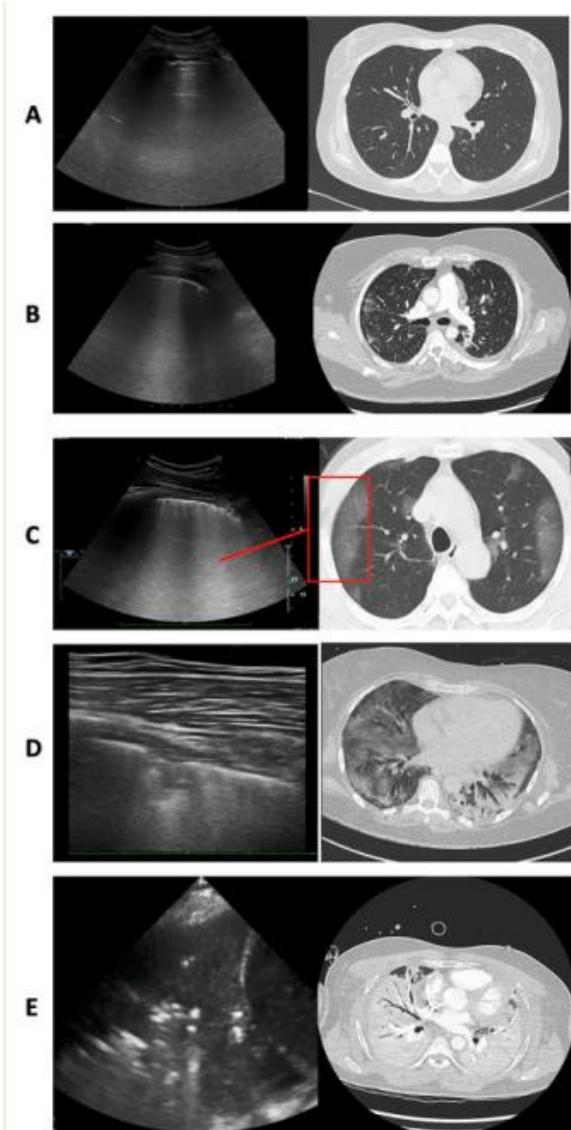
LUS findings correlated to chest CT progressing from normal aeration (A), to progressively more deaerated conditions: coalescent B-lines (B and C), small peripheral consolidation (D),large consolidation (E). The red box in (C) shows an area of groundglass opacification on CT corresponding to confluent B-lines on LUS.
